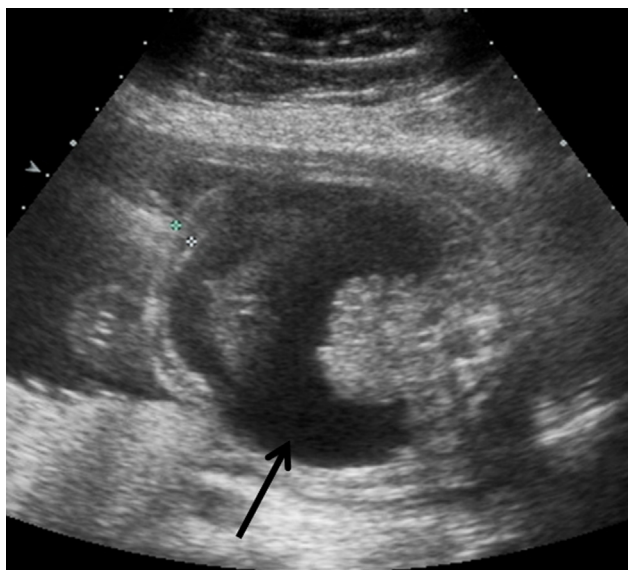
Fetal hydrops. Transverse view of the fetal abdomen obtained as part of a fetal ultrasound scan. There is a large volume of ascites (arrow) and skin thickening (calipers), which is consistent with nonimmune fetal hydrops. (Available in color online at www.jvir.org.)
